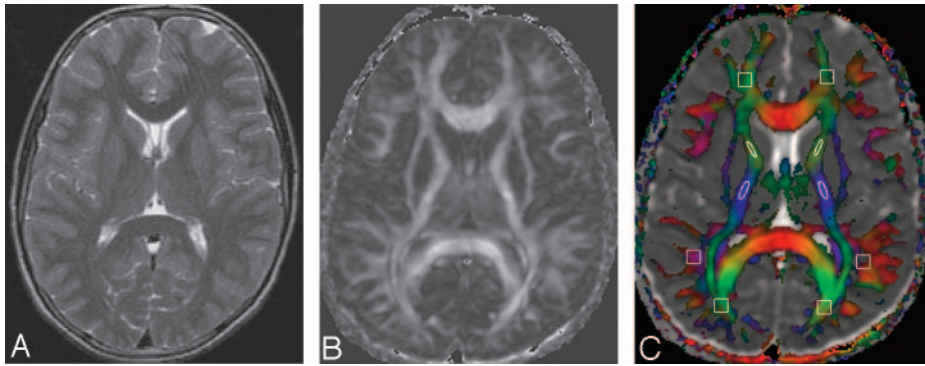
A 6-year-old healthy control. T2-weighted (A), FA (B), and color-coded FA images fused with apparent diffusion coefficient (ADC) maps (C) through the lateral ventricles show normal distribution of white matter. The rectangular and elliptic ROIs are placed (C) on the frontal, parietal, and occipital cerebral lobes and the posterior limb of the internal capsule for quantification of FA and MD values. The cutoff value for the color-coded FA for display is kept at 0.2 (C), above which the color-coded regions reflect the white matter only (red [right–left], green [anteroposterior], and blue [superior–inferior]).
